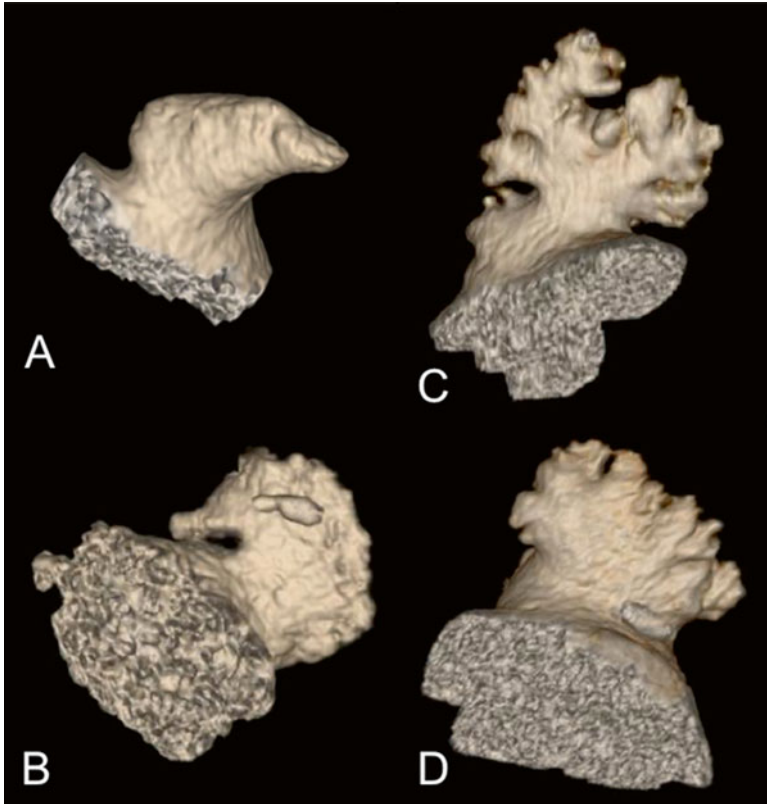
CT images of the four most common shapes of LAA: (a) windssock, (b) chicken-wing, (c) cactus, and (d) cauliflower
